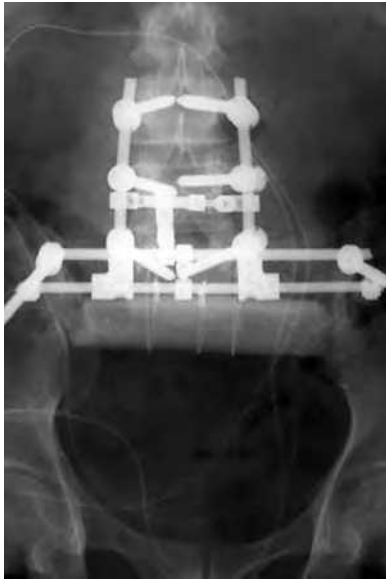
Postoperative X-ray, depicting the updated modified Galveston technique.
